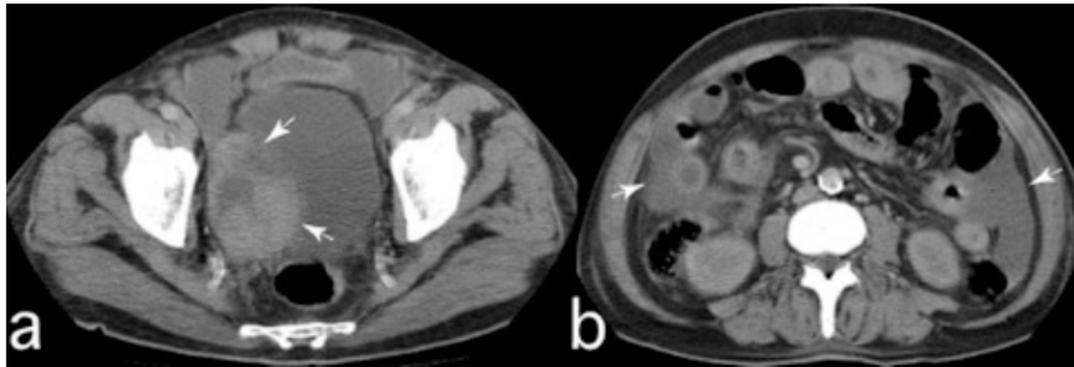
Abdominal CT examination; a) pelvic sections showing a mass (arrows) laterally adjacent to the right margin of the urinary bladder with partially smooth margins and central necrotic areas, which, on first sight, suggests an origin in the bladder wall. b) Abdominal CT sections of the same patient showing the presence of free fluid between the segments of the small intestine and in bilateral paracolic areas (arrows).
